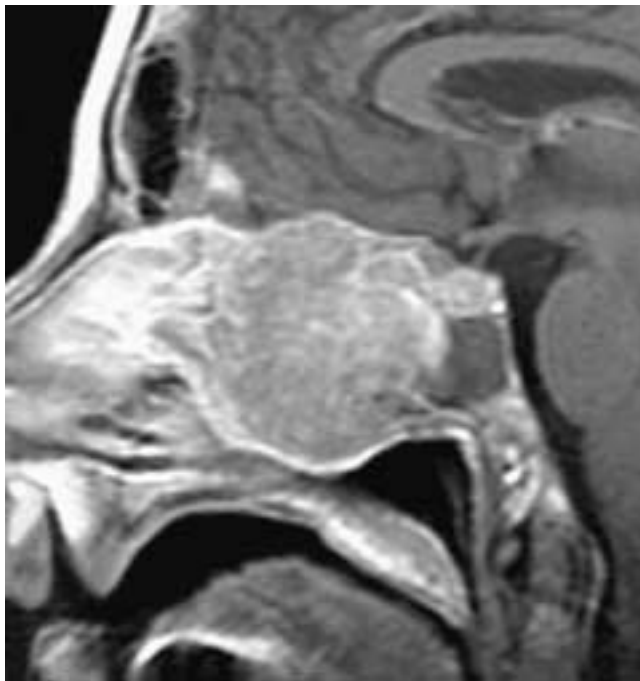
Sagittal T1-weighted, fat-suppressed, contrast-enhanced MR image shows an enhancing nasal septal mass that has extended into the sphenoid bone. A mucocoele is present within the obstructed sphenoid sinus. This patient had a chondrosarcoma.
